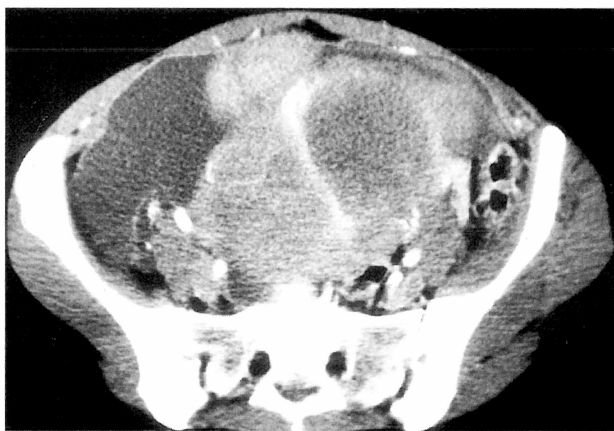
and Figure 3. — Computed tomography of abdomen after administration of contrast agent shows inhomogeneous enhancement in the solid part of tumor. Free fluid is also present.
